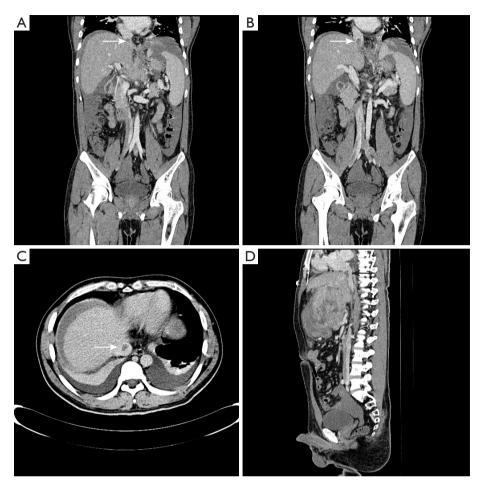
A 60-year-old male, patient with type II HCCIVCTT. Preoperative enhanced CT scan: (A,B) coronal views showed a large mass lesion in the hepatogastric space, closely related to the left lobe of the liver, which was suggestive of exophytic primary hepatocellular carcinoma with hemorrhage. Patchy tumor thrombus (arrow) was observed in the inferior vena cava, extending beyond the diaphragm level but not entering the right atrium. (C) Axial view showed patchy tumor thrombus (arrow) in the inferior vena cava. (D) Sagittal view showed patchy tumor thrombus (arrow) in the inferior vena cava tumor thrombus; CT, computed tomography.
